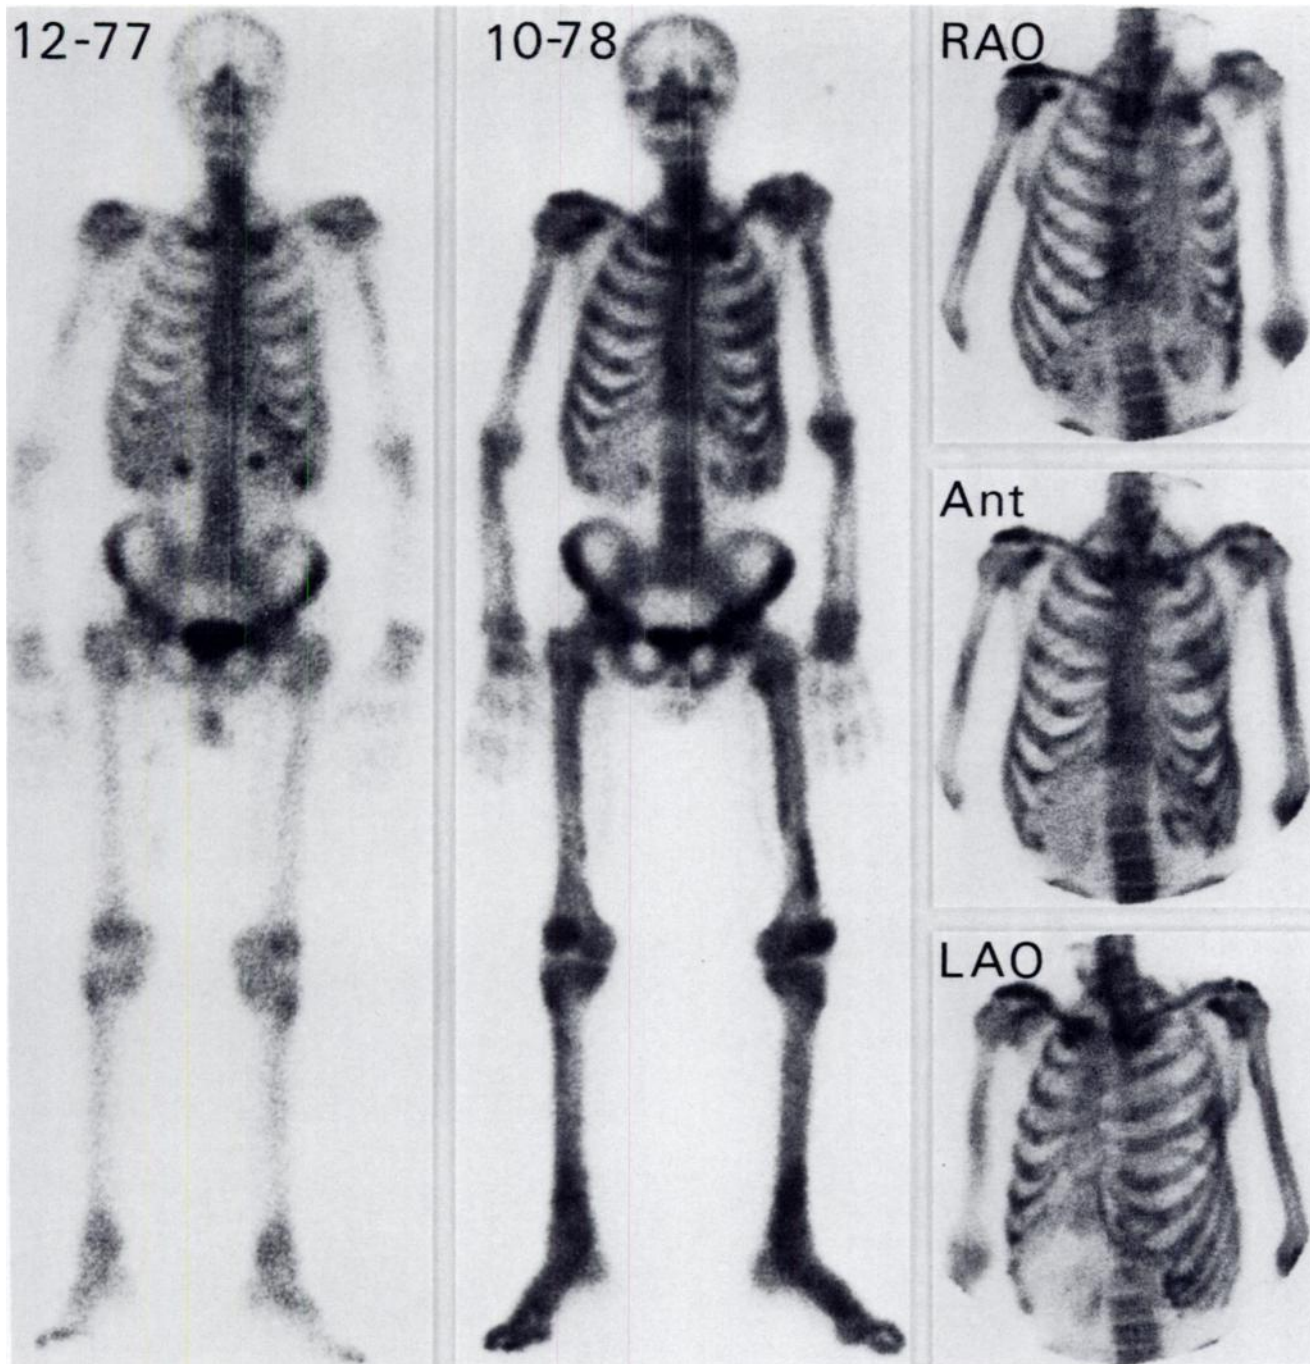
71-year-old man, status post resection of carcinoma of lung. Bone scintigram normal 12-77. Recurrence of lung tumor 10-78; bone scan demonstrates hypertrophic pulmonary osteoarthropathy. Malar bones, ribs, and extremities are involved.
